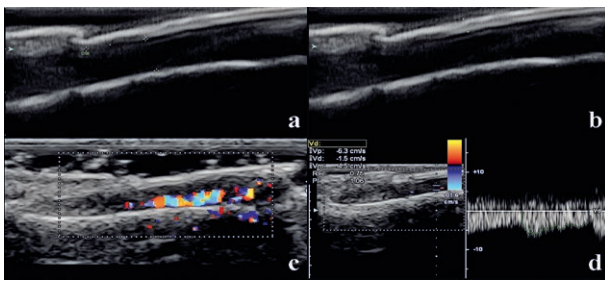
US aspect in a 59 years old male with psoriasis and with clinical affected nails: a) 2D US – thick-ness of the nail bed; b) 2D US – measurements of the nail plaques thickness; c) color Doppler US – tortuous vessels in the nail bed; d) spectral Doppler – Doppler indices in nail vessels
